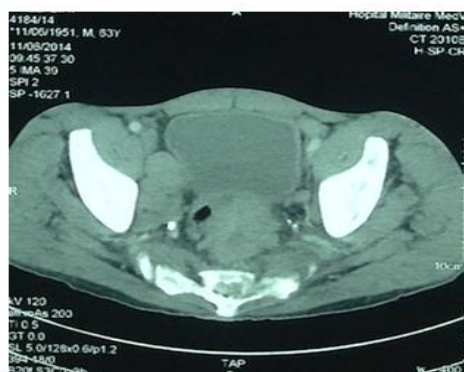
Image showing a CT enlarged prostate.
